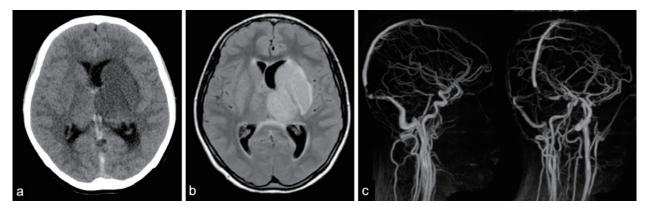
(a) Computed tomography scan showing hyperdense signals in the internal cerebral veins (ICVs), vein of Galen (VG), straight sinus (StS), and torcular herophili (TH). (b) Fluid-attenuated inversion recovery (FLAIR) reveals high-intensity lesions mainly in the left thalamus, basal ganglia, and corpus callosum. (c) Magnetic resonance venography showing a venous flow defect in the ICVs, VG, StS, TH, and right transverse sinus.
